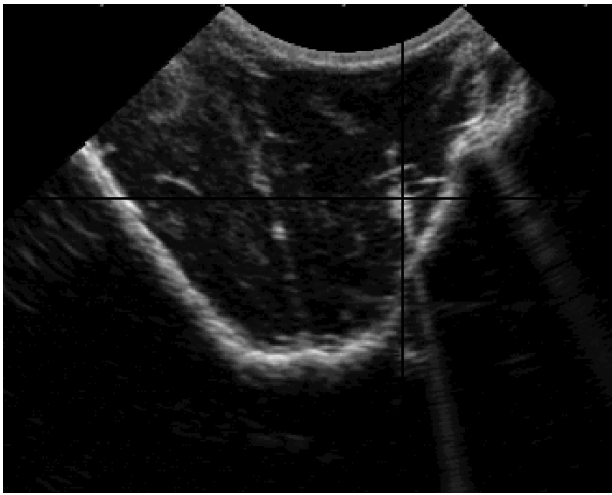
depicts an US image and its corresponding oblique CT reconstruction. The crosshairs in both images are set to the coordinates found using the semi-automatic bead extraction algorithm described in Section II-B.
